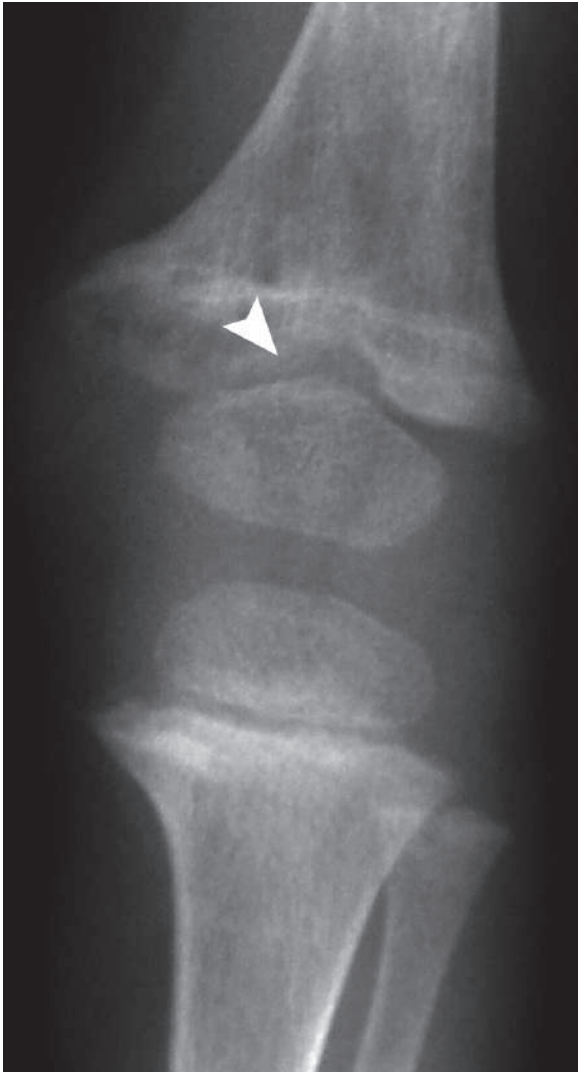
Anteroposterior plain radiograph of the left knee in a child with rickets shows focal cupping of the distal femoral metaphysis (*arrowhead*)
